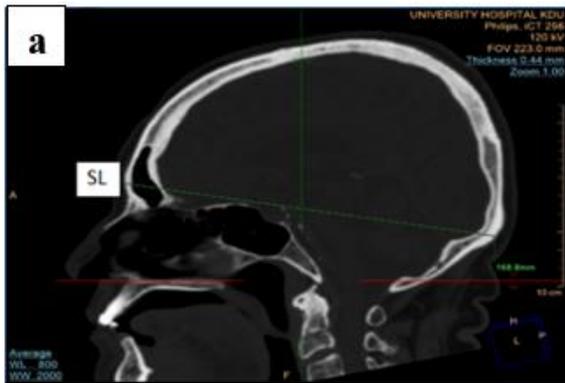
CT image showing the SL
